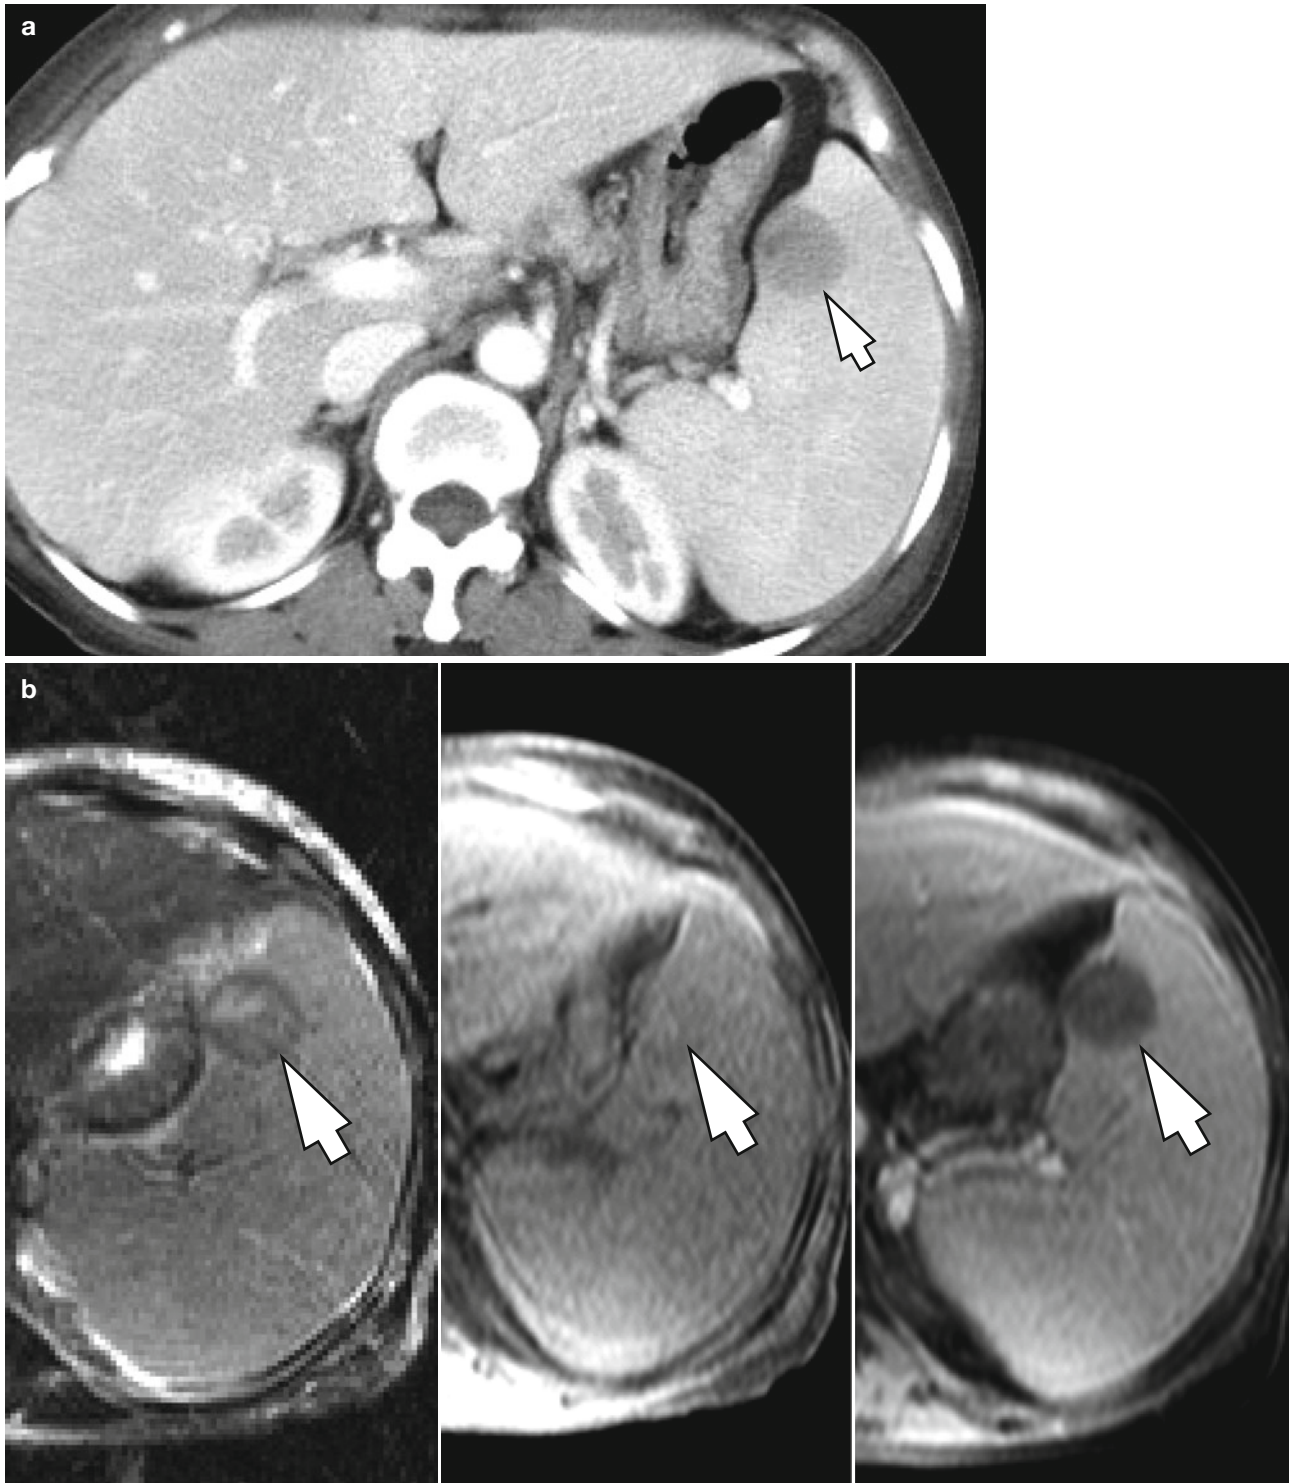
A 77-year-old female with diffuse large B-cell lymphoma. (a) Contrast-enhanced transverse CT image demonstrates a 2.5 cm hypoattenuating mass (arrow) in the spleen. (b) The lesion (arrows) shows heterogeneous high signal intensity on T2-weighted transverse
